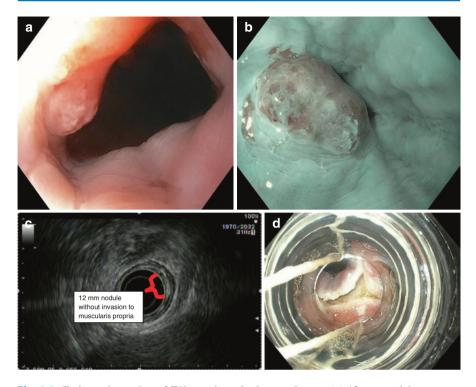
Endoscopic staging of T1b esophageal adenocarcinoma. (a) 12 mm nodular mass at Z-line. (b) The same lesion visualized under narrow band imaging. (c) Endoscopic ultrasound showing the lesion not invading the muscularis propria. For this reason, endoscopic mucosal resection was indicated for staging. (d) Endoscopic mucosal resection of the lesion
